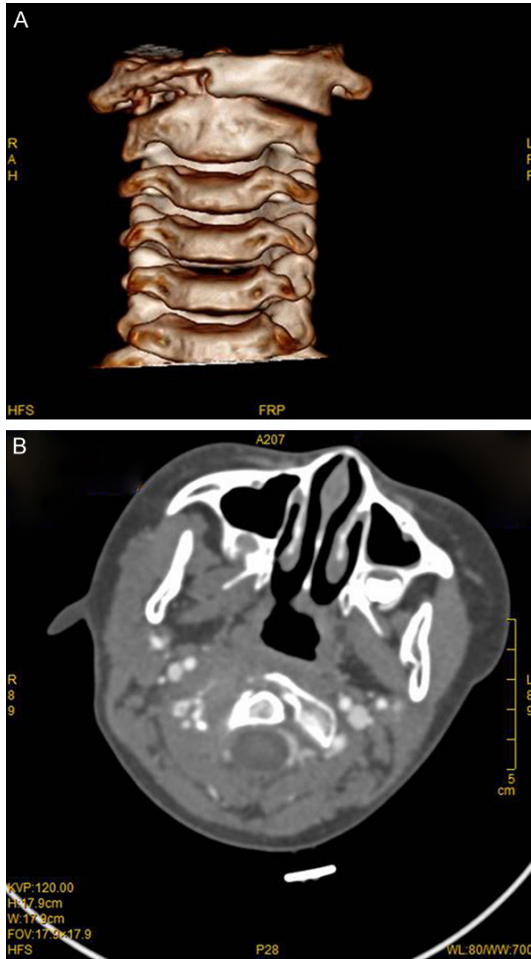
A. Preoperative axial cervical spine enhanced computed tomography (CT) film showing atlanto-axial vertebral bone destruction filled with soft tissue. B. Preoperative cervical spine 3D reconstruction showed atlanto-axial vertebral bone destruction.
